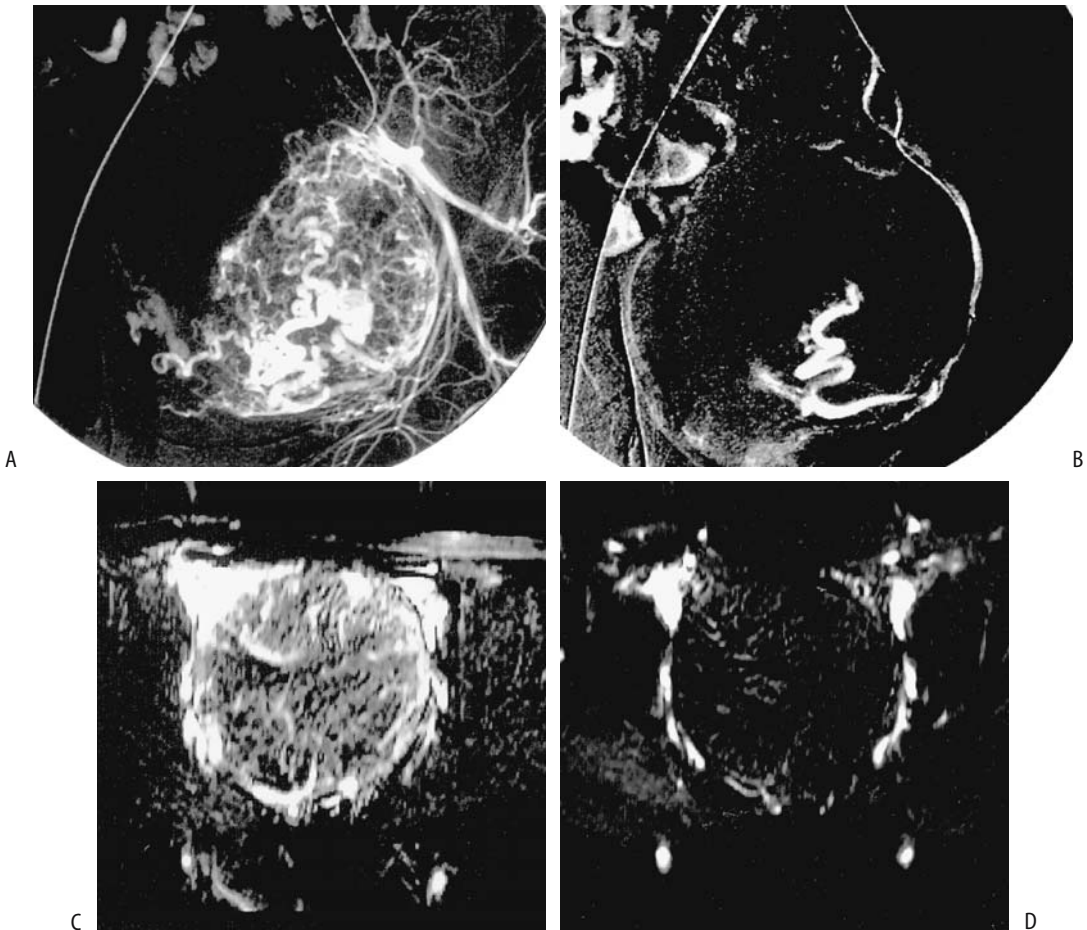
Uterine fibroid embolization. Shown are arteriograms before (A) and at the end of uterine fibroid embolization (B) and corresponding MR images before (C) and 1 day after embolization (D). MR images were obtained with an extraslice spin tagging technique, which evaluates tumor perfusion and tumor volume without the use of contrast. Serial posttherapy MR images revealed a decrease in original tumor size. (Source: Hagspiel KD, Matsumoto AH, Berr SS. Uterine fibroid embolization: assessment of treatment response using perfusion-weighted extraslice spin tagging (EST) magnetic resonance imaging. *J Magn Reson Imaging* 2001;13:982–986, with permission from Wiley-Liss, a subsidiary of John Wiley & Sons.)
